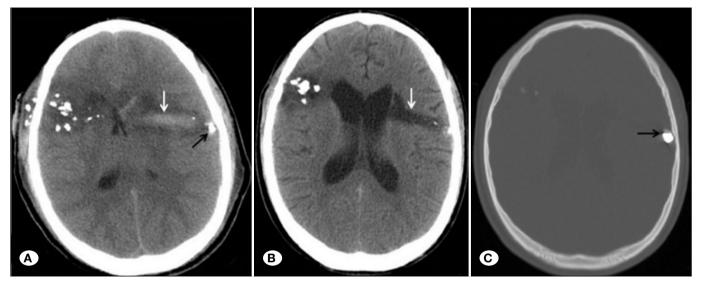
A) Multiple bone fragments in the right frontal lobe, collapsed lateral ventricles, intracerebral hemorrhagic contusion in the left frontal lobe (white arrow) and bullet and accompanying bone fragment in the left frontal cortex (black arrow) on initial CT scan of the patient, B) Multiple bone fragments in the right frontal lobe and slightly enlarged lateral ventricles, hypodense area due to the resorption of the hemorrhagic contusion in the left frontal lobe (white arrow) in the follow-up CT scan after 2 months, C) Bullet and accompanying bone fragment (black arrow) in bone-window CT scan.
